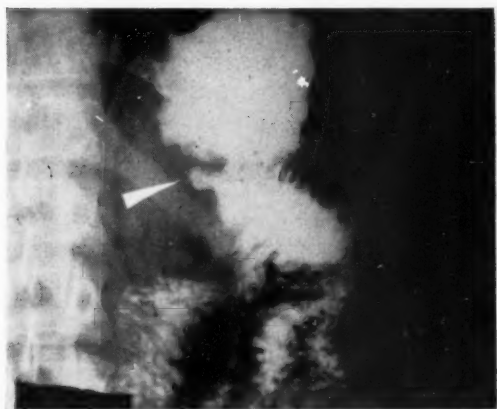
Case A.D., 8 June 1954. Gastrojejunal ulcer. Serial x-ray views showing stages of healing during DAA therapy.
